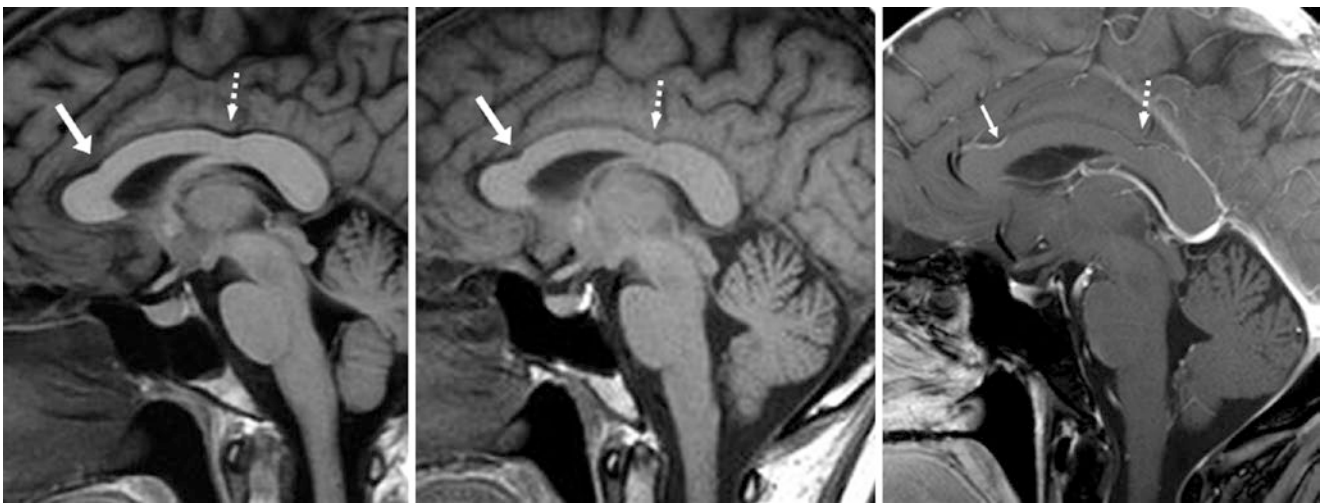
A 45 year old who underwent a 1.5T MRI demonstrating normal, mild compression of the callosal posterior genu- anterior body (arrows) from a pericallosal artery (thin arrow) on a sagittal midline T1WI (left). This was unchanged 8 years later on pre- (middle) and postcontrast (right) T1WIs. Note a normal callosal isthmus posteriorly (dotted arrows)
